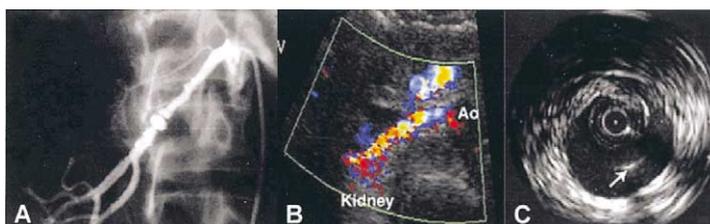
(A) Classic “chain of beads” angiographic appearance. (B) Transverse view at the level of the origin of the right renal artery. There is laminar flow in the proximal segment 1 cm (blue) beyond which flow is turbulent (multicolored mosaic pattern). (C) Intravascular ultrasound in the middle segment of the right renal artery, demonstrating a membrane (arrow). Ao = aorta.
